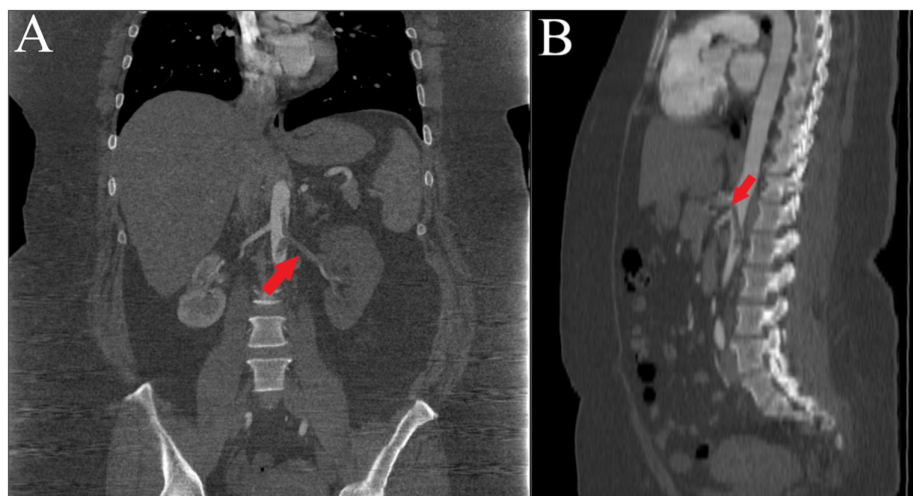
Contrast-enhanced computed tomography of the abdomen. (A) Thrombus from the aorta extending into the left renal artery with secondary extensive renal infarct (red arrow). (B) Partial occlusive thrombosis of the aorta extending into the celiac artery (red arrow).
